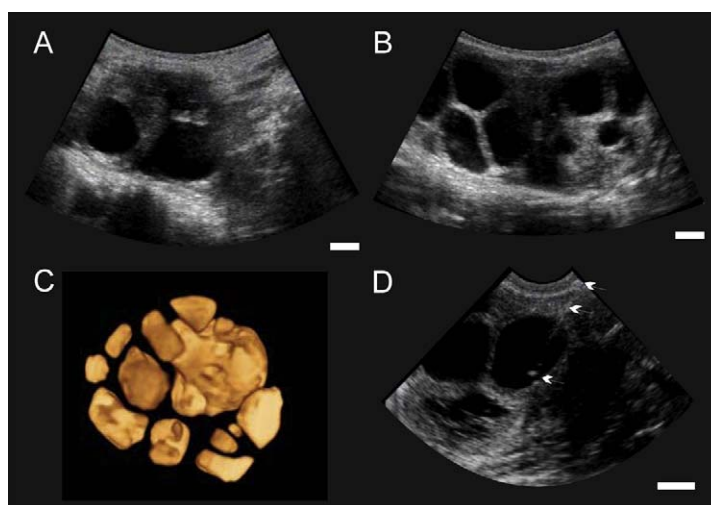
Ultrasound images of anestrus black rhinoceros and superovulated black rhinoceros. (A) Ovary in anestrus with two large follicles. (B) Ovary with multiple large follicles after stimulation with GnRH analogue. (C) Inverse mode three-dimensional ultrasound reconstruction of the ovary. Grey-colored area represent fluid-filled follicles. (D) Aspiration needle has penetrated the rectal wall and ovarian tissue and is situated in the follicular lumen (arrows).
